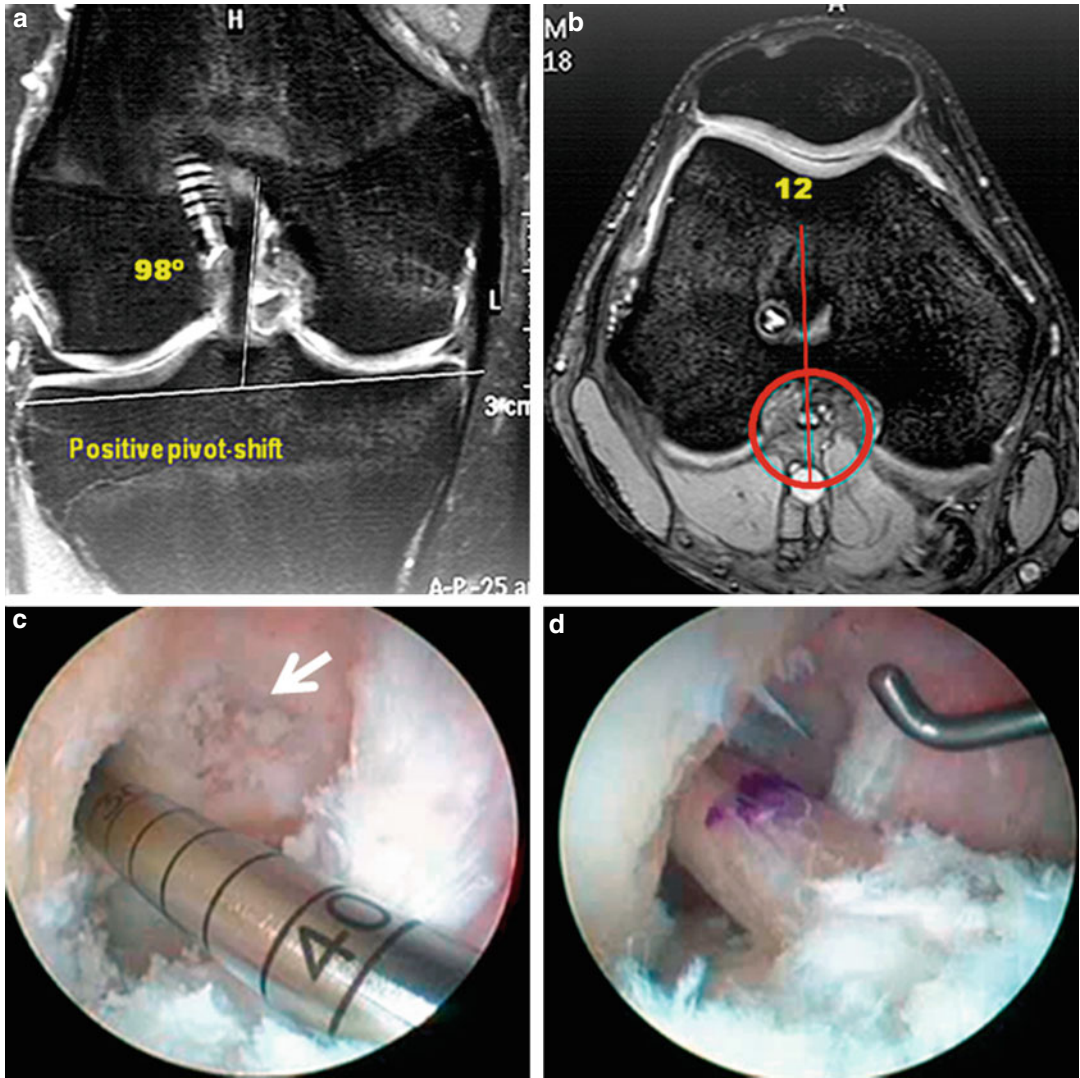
This is the case of a patient with a vertical graft orientation and non-satisfactory clinical result (positive pivot-shift). (a) Coronal MR image. Vertical graft orientation. (b) Axial MR image. High noon femoral tunnel
